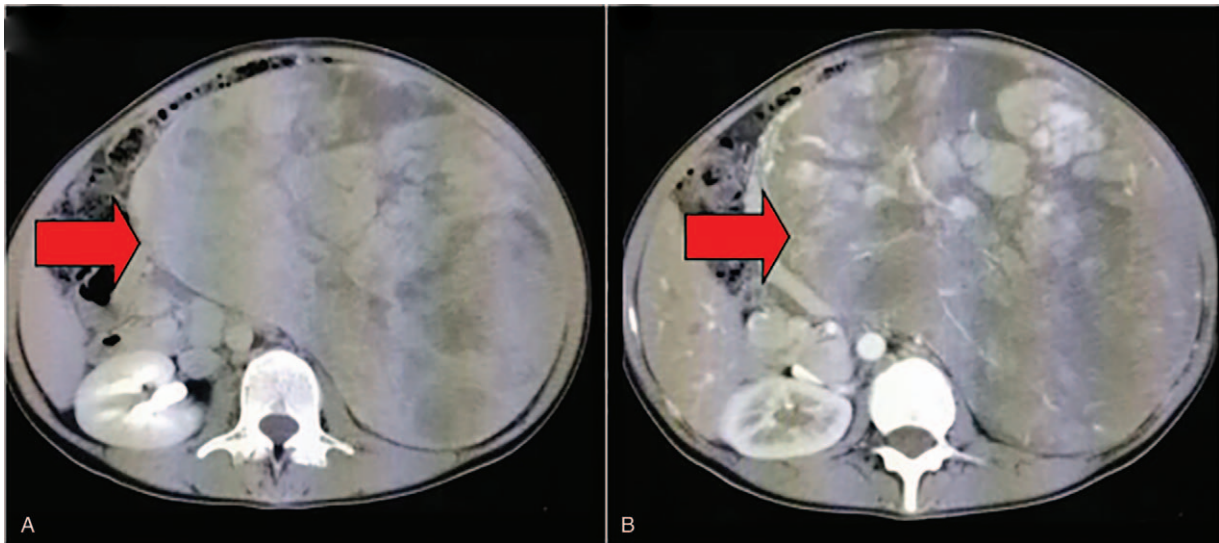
Computed tomography of the abdomen. (A) Conventional scanning reveals the left abdominal cavity with a diameter of approximately 20 cm (arrowhead). (B) Enhancement scanning reveals the lesions is not uniform and obvious (arrowhead).
